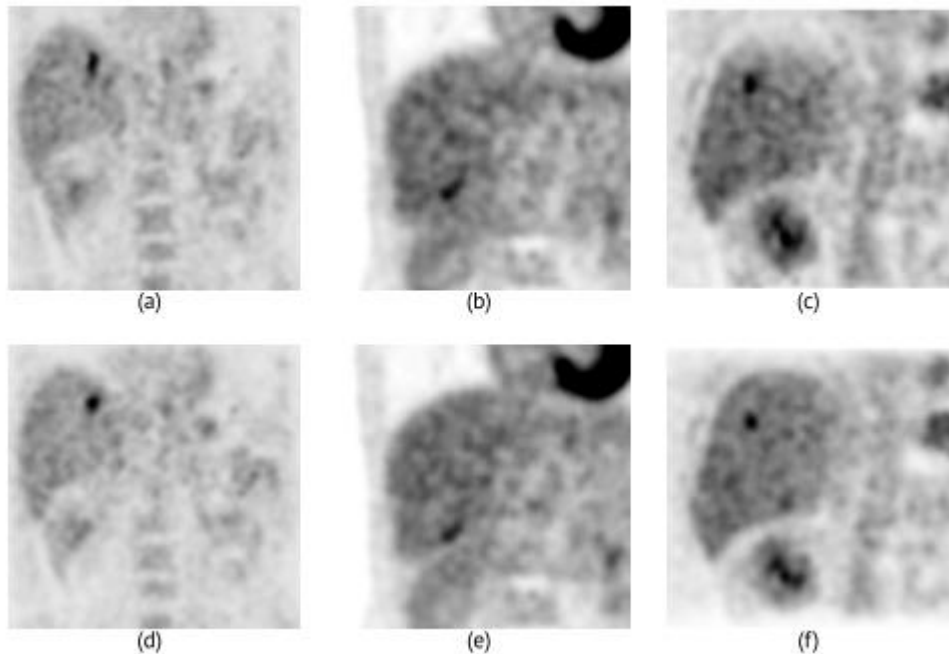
Three patient examples of differences between 3D-PET/CT images (top) and respiratory compensated PET/CT images (bottom). In the first patient (a),(d) it is clearly seen that Tumor activity is more focused after motion compensation. In the second patient, (b),(e) a more clear distinction between the liver and the kidney is seen. In the third patient, (c),(f) the target lesion is more clearly delineated after motion compensation [49].
